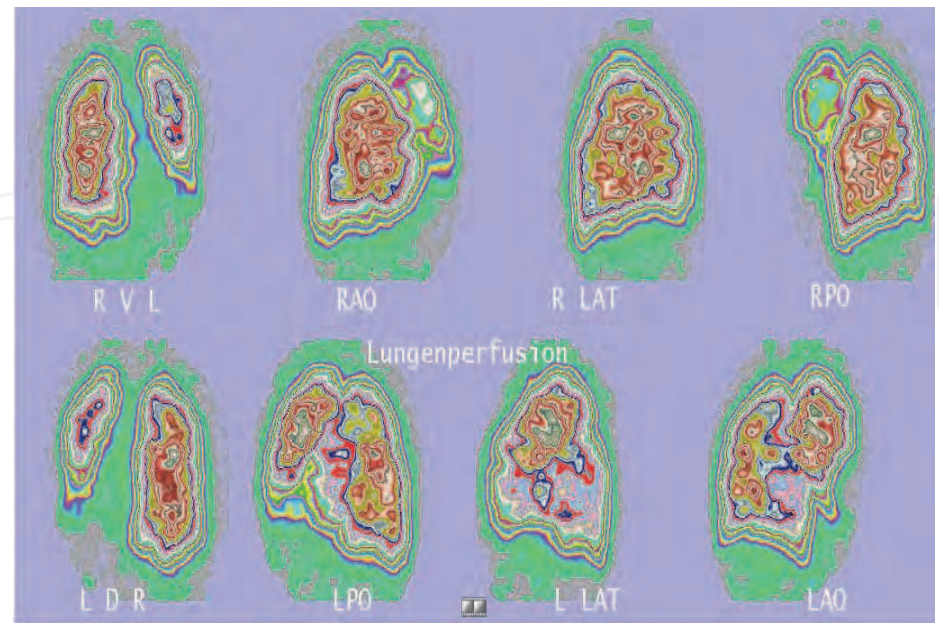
Scintigram of the lungs after i.v. administration of a radionuclide (^{99m}Tc). From a higher number of such projection images a 3D-SPECT perfusion image can be reconstructed.
